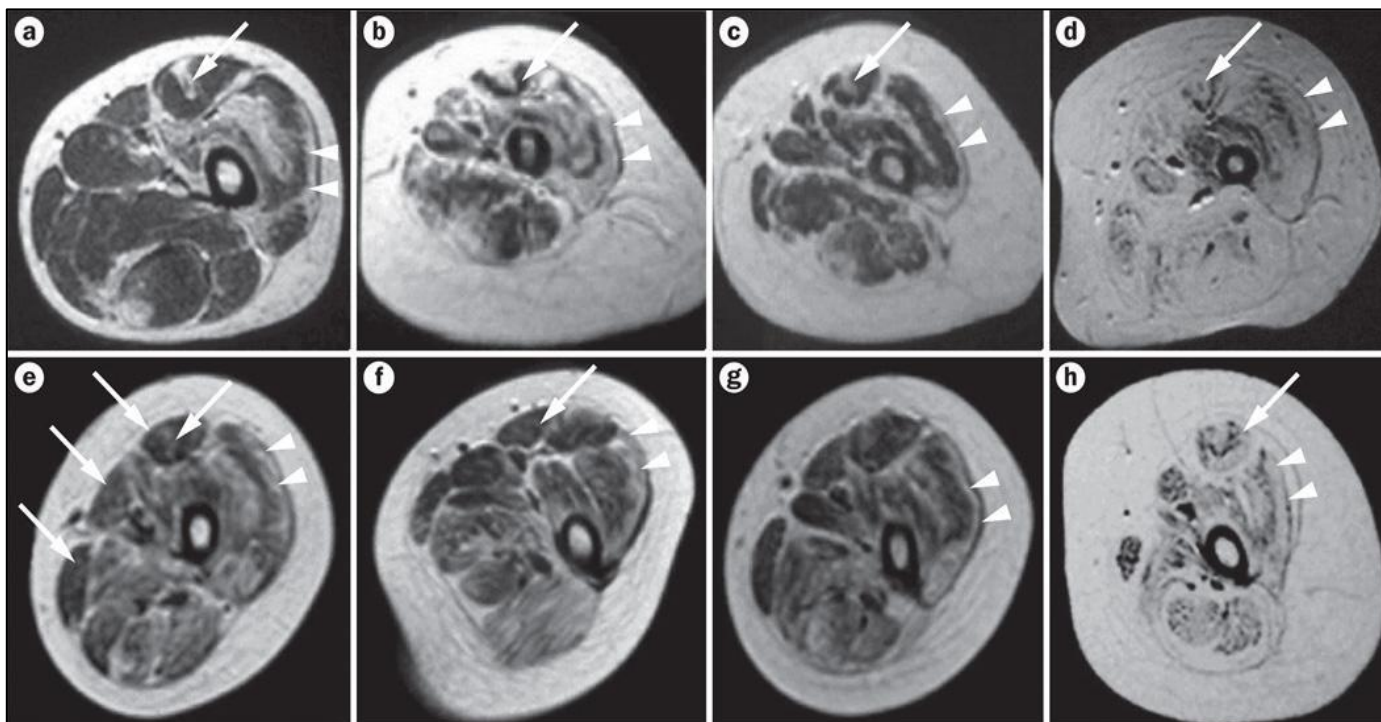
Muscle MRI findings in collagen VI-related myopathies reveal distinct patterns. T1-weighted MRI scans of the thigh in patients with (a–d) Bethlem myopathy and (e–h) Ullrich congenital muscular dystrophy of varying severity demonstrate characteristic fatty degeneration (highlighted as white areas). Notably, this degeneration appears along the fascia in the center of the rectus femoris (long arrows) and around the rim of the vastus lateralis (arrowheads), forming the characteristic ‘outside-in’ pattern. This pattern persists in patients with severe forms of the disease, as seen in parts d and h. Permission obtained from Elsevier Ltd © Mercuri, E. *Neuromuscular. Disord.* 15, 303–310 (2005).
